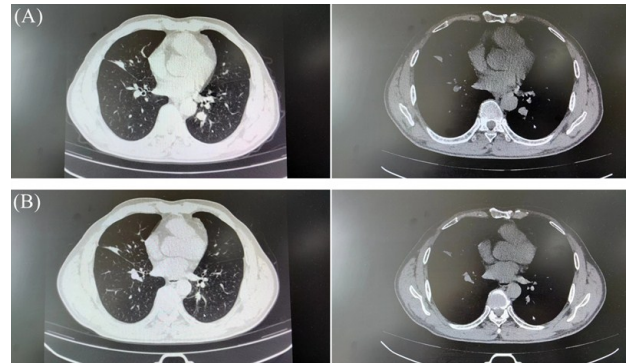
CT findings of a patient before and after treatment (male, 67 years old). (A) Images of the lung window and mediastinal window before treatment. (B) Images of the lung window and mediastinal window after treatment.
